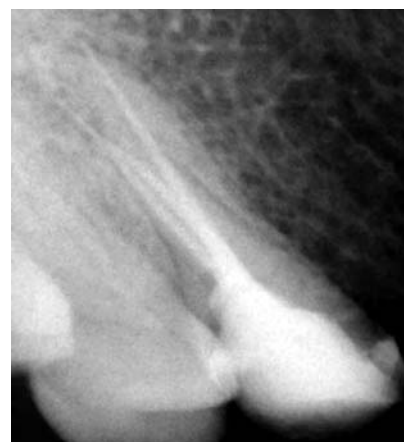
Off-angled radiograph shows 3 filled canals
